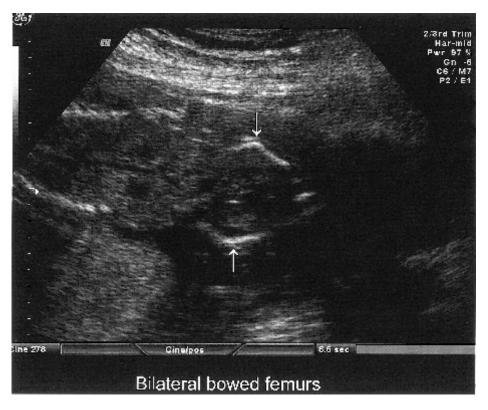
Sonogram of a 16-week, 6-day-old fetus with bilateral bowed femurs.
